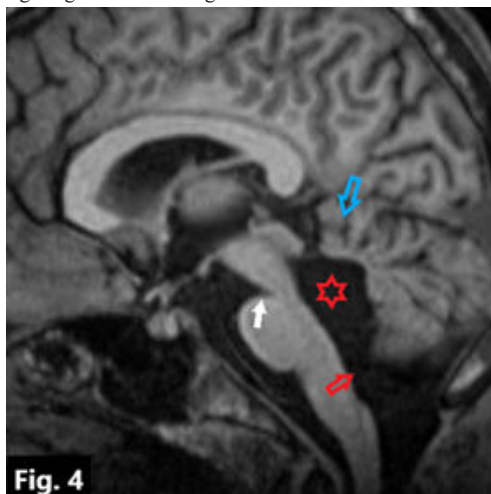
MRI T1 WI sagittal section showing narrow pontomesencephalic junction (white arrow) with dilated fourth ventricle and a deformed roof (red asterisk). Cerebellar vermis appears dysplastic (blue arrow). Foramen of Magendie is wide opening into the cisterna magna (red arrow).
